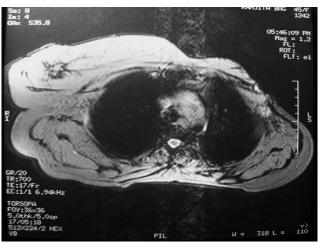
MRI Thorax showing extent of mass and chest wall involvement.
